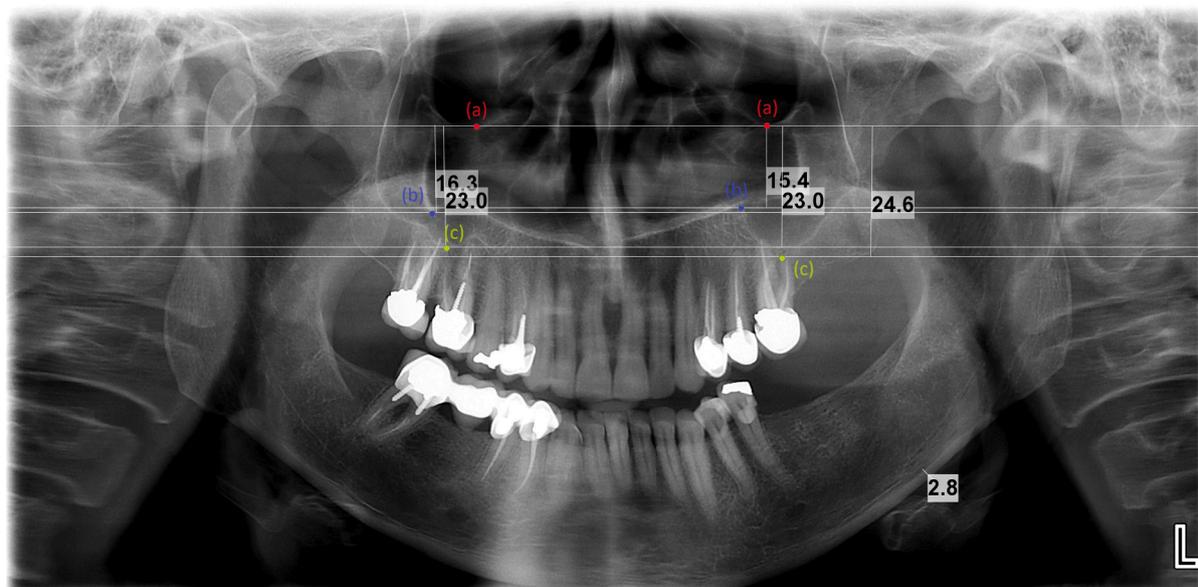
Panoramic radiograph of a patient with osteoporosis (Inferior mandibular cortex thickness of 2.8 (mm)). (a) Most inferior points of the orbits and their connecting line (b) Most inferior points of the zygomatic process (c) Most inferior points of the maxillary sinus.
